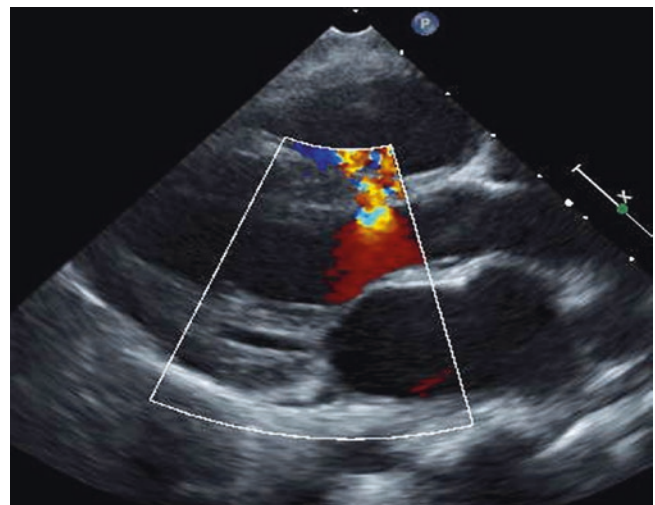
Parasternal long-axis echocardiogram with Doppler color flow mapping view of a small to moderate perimembranous ventricular septal defect. The direction of flow is from the left ventricle to the right ventricle
